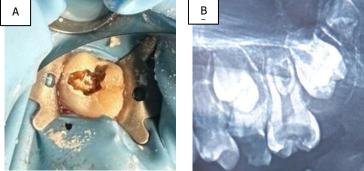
Pre-operative condition; a. pre-operative clinical view of tooth 26, b. pre-operative radiograph of tooth 26
